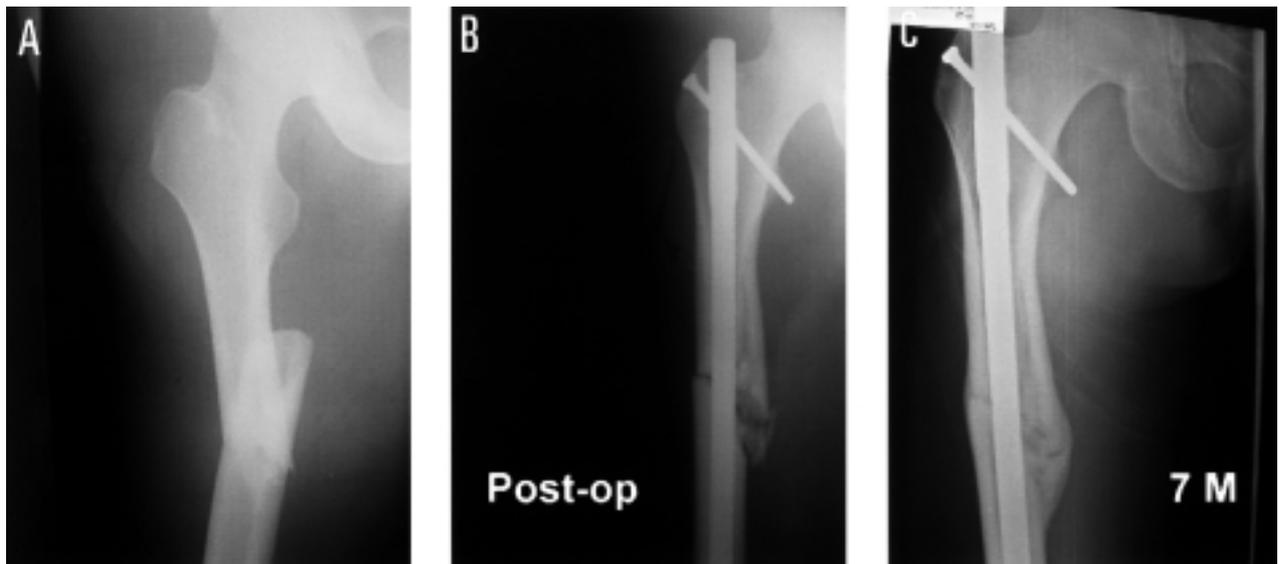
(A) Preoperative radiograph of a Winquist-Hansen type 0 fracture. (B) The fracture comminution became Winquist-Hansen type 2 intraoperatively. (C) The fracture healed 7 months later after interlocking nail fixation.
